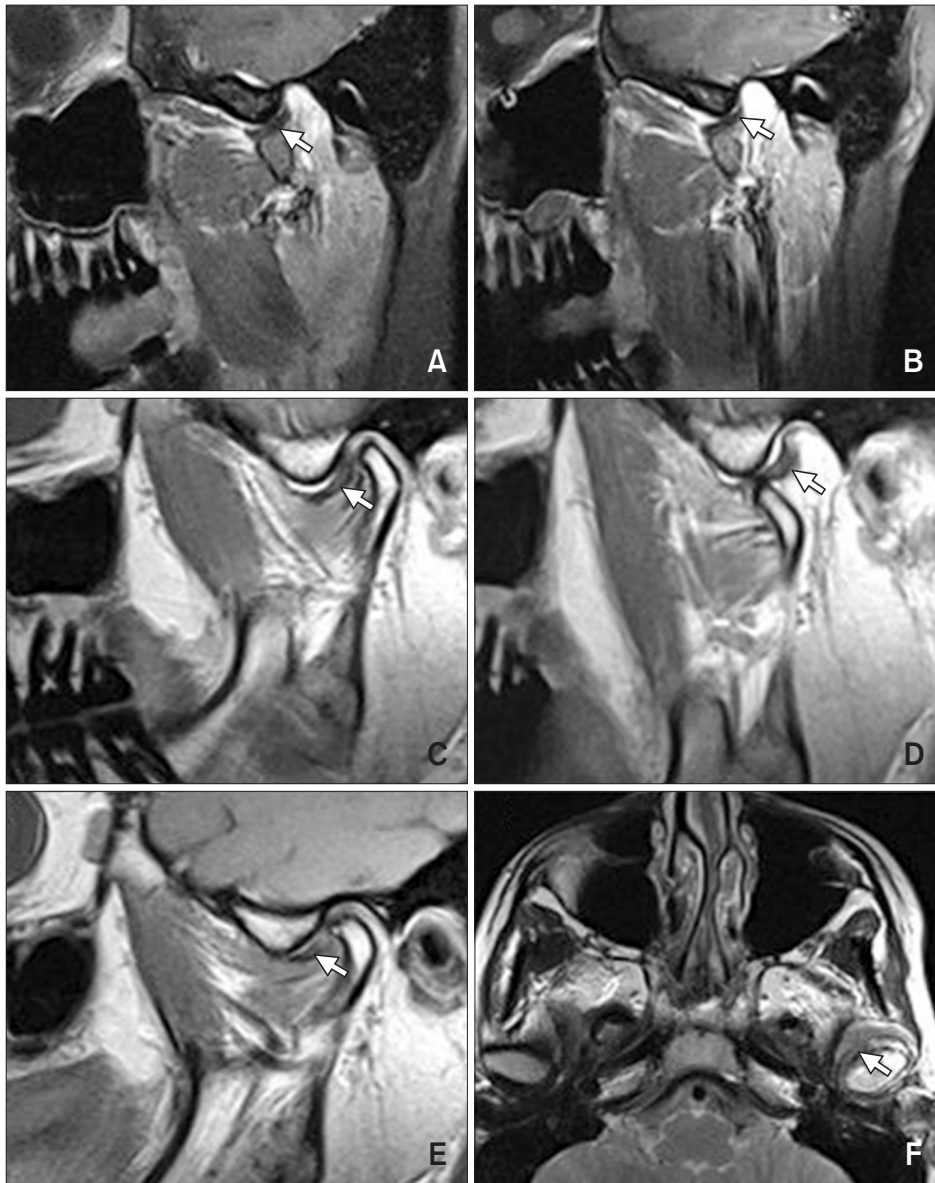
Magnetic resonance imaging (MRI) findings of disc degeneration. MRI findings show degree of disc degeneration and synovitis. (A) Normal elasticity of disc (arrow). (B) Degeneration of disc, loss of elasticity (arrow). (C) Total anterior displacement, acute phase (arrow). (D) Total anterior disc displacement with reduction acute phase (arrow). (E) Total anterior disc displacement, chronic phase (arrow). (F) Synovitis in juvenile temporomandibular joint (arrow).
